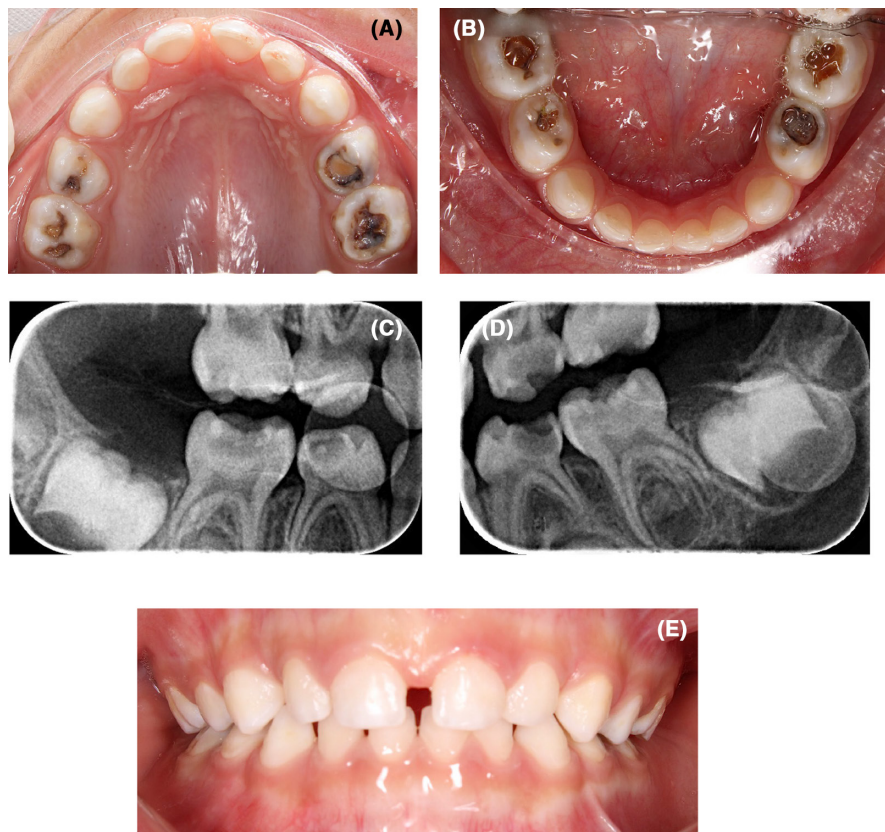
Clinical and radiographic presentation of the patient's oral cavity before full mouth rehabilitation: (A) and (B) Clinical presentation of the upper and lower views of the dental arches; (C) and (D) Radiographic bitewings presenting the upper and lower posterior teeth; (E) Frontal view of the patient's teeth.
